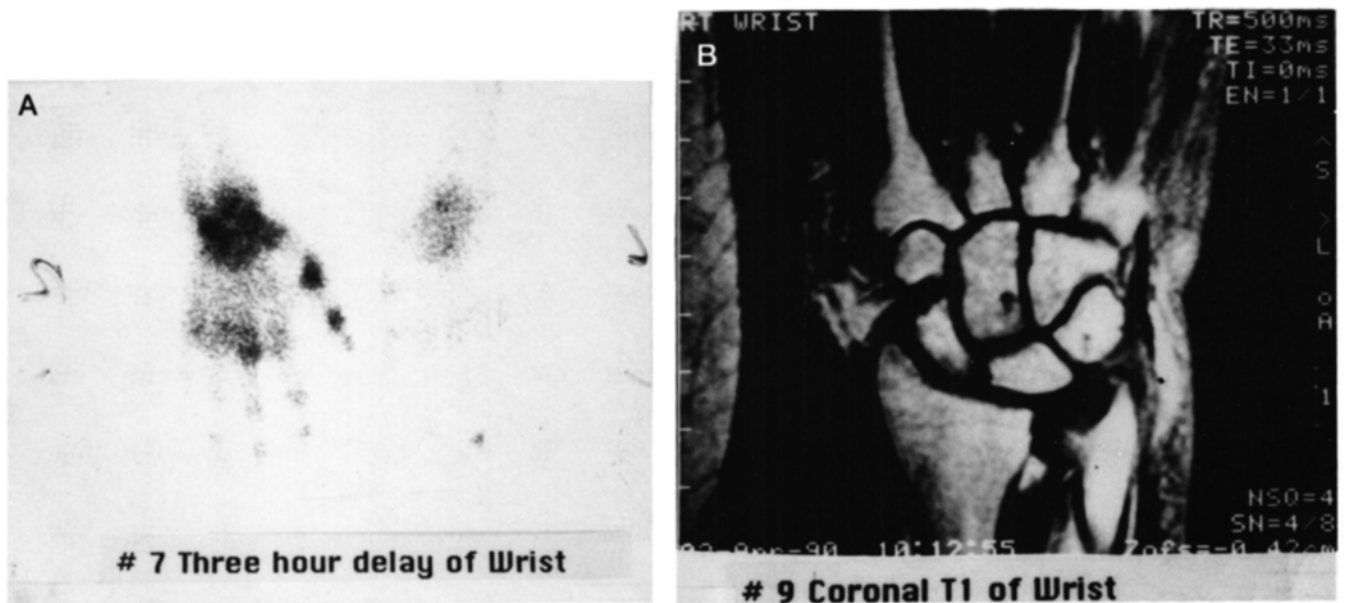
(A) Three-hour delayed bone scan of hand and wrist demonstrating increased activity corresponding to (B) area of soft-tissue swelling on MRI image. (Courtesy of A. Lesselroth, MD, Mountain Diagnostics, Las Vegas, NV.)
